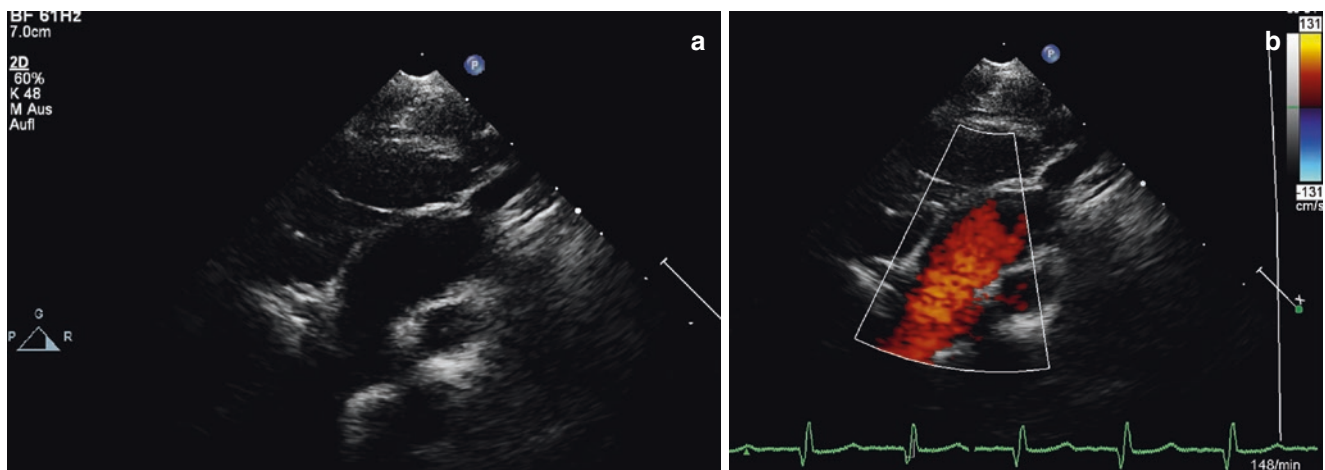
The high right parasternal longitudinal view (a) shows the superior vena cava (SVC) draining into the right atrium (RA) with its course anterior to the right pulmonary artery, which is displayed in cross section (arrow); colour Doppler displays flow in the vena cava (b)
